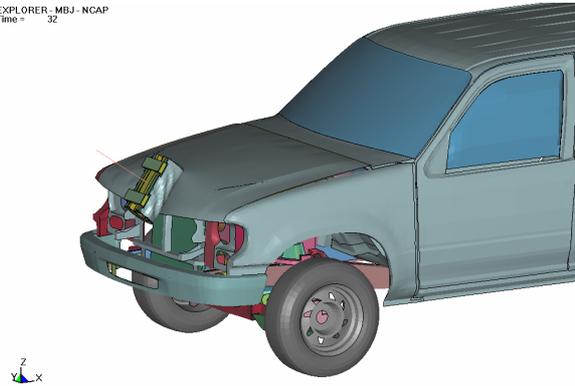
SUV and upper legform FE model.
